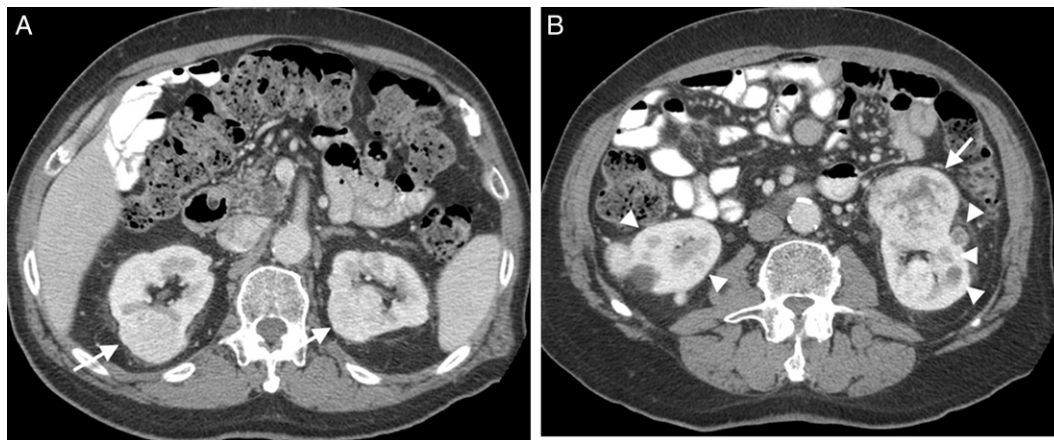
Male patient, 73 years old, with incidental diagnosis of bilateral renal masses. Axial contrast enhanced CT through mid kidneys showed numerous bilateral solid enhancing renal masses (A). Axial contrast enhanced CT revealed dominant mass in posterior lower pole of left kidney measuring up to 4 cm (B, arrow). Lesion diagnosed as chromophobe RCC on surgical pathology.
